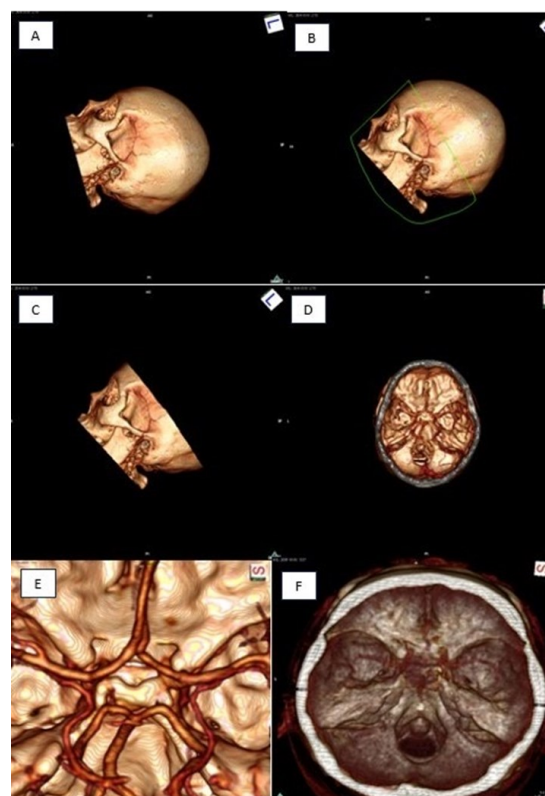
A: The 3D image after reconstruction. B: The direction of cutting the image. C: The image obtained after cutting. D: The image rotated to visualize the circle of Willis. E: An example of the zoomed image. F: An example of excluded images of the suboptimal CTA due to poor contrast.
